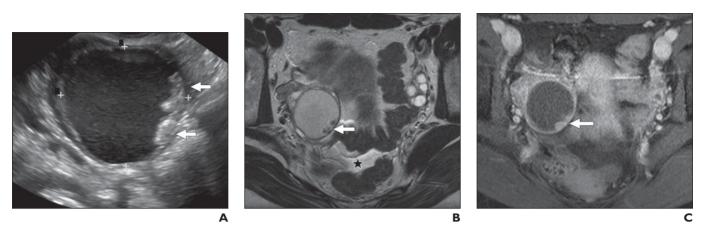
Serous borderline tumor of ovary in 28-year-old woman. A, Transvaginal ultrasound image reveals 3.5-cm cystic lesion with mural nodularity (*arrows*). B and C, Fast spin-echo T2-weighted (B) and gadolinium-enhanced (C) axial MR images show solid nodules (*arrows*) enhancing with contrast material. Trace physiologic amount of free fluid (star, B) is noted.
